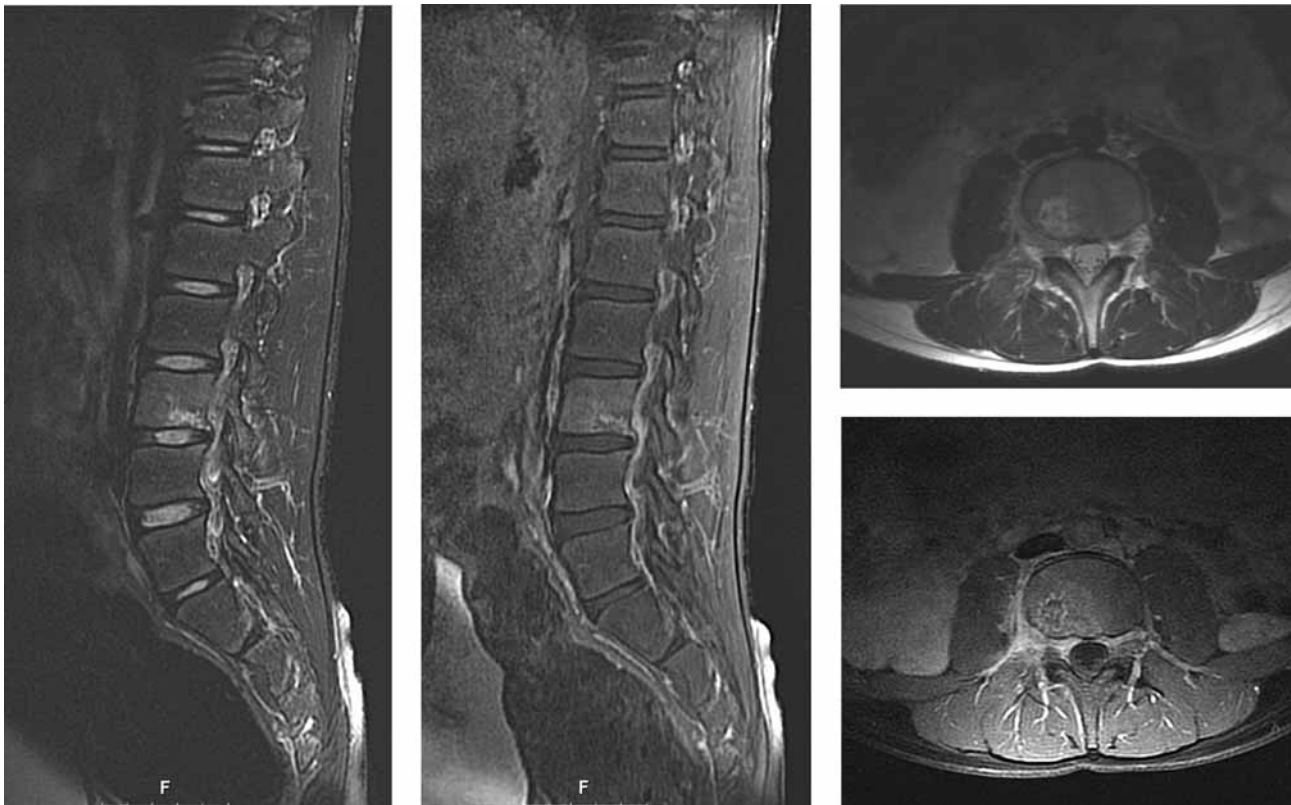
The sagittal T2-weighted image (2540/108) shows diffuse heterogeneous enhancement in L3 vertebral body, which is iso-intense to adjacent normal vertebrae and a sharply circumscribed area of inflammation dorsocaudally, which is extending to L3-4 disk space.
